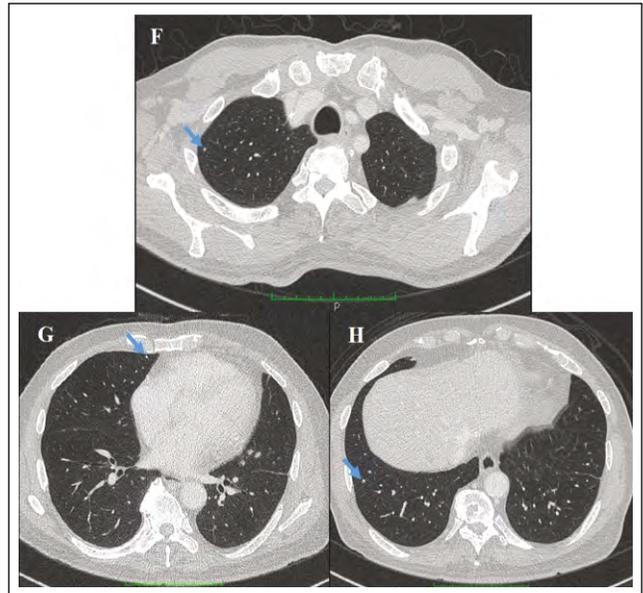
Axial CT thorax in lung window showing tiny nodules (blue arrow) in the right apex (F), medial segment of the right middle lobe (G), and lateral segment of the right lower lobe (H).
